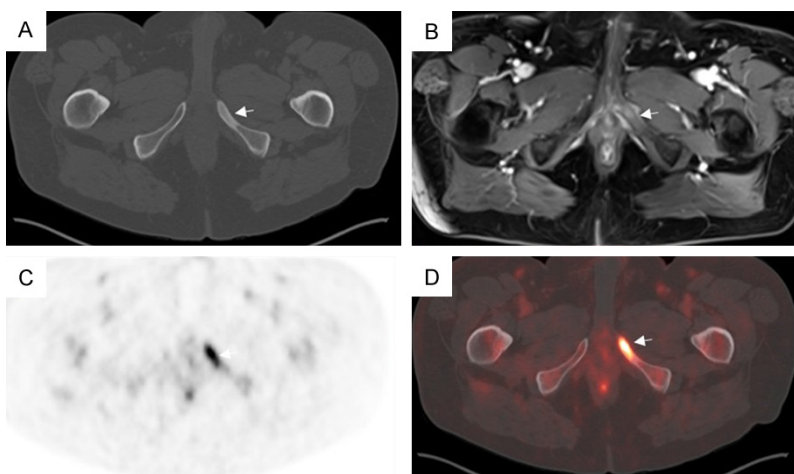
59-year-old man with Gleason 4+5 prostate adenocarcinoma, status post radical prostatectomy, with rising serum PSA from previous undetectable level. Serum PSA at the time of presentation was 0.09 ng/mL. Axial CT (A), axial post-contrast T1-weighted MR (B), axial ¹⁸F-Fluciclovine PET (C) and axial fused ¹⁸F-Fluciclovine PET/CT (D) demonstrates a sclerotic, enhancing lesion in the left inferior pubic ramus (white arrows) which demonstrates focal increased radiotracer uptake, consistent with osseous metastasis.
